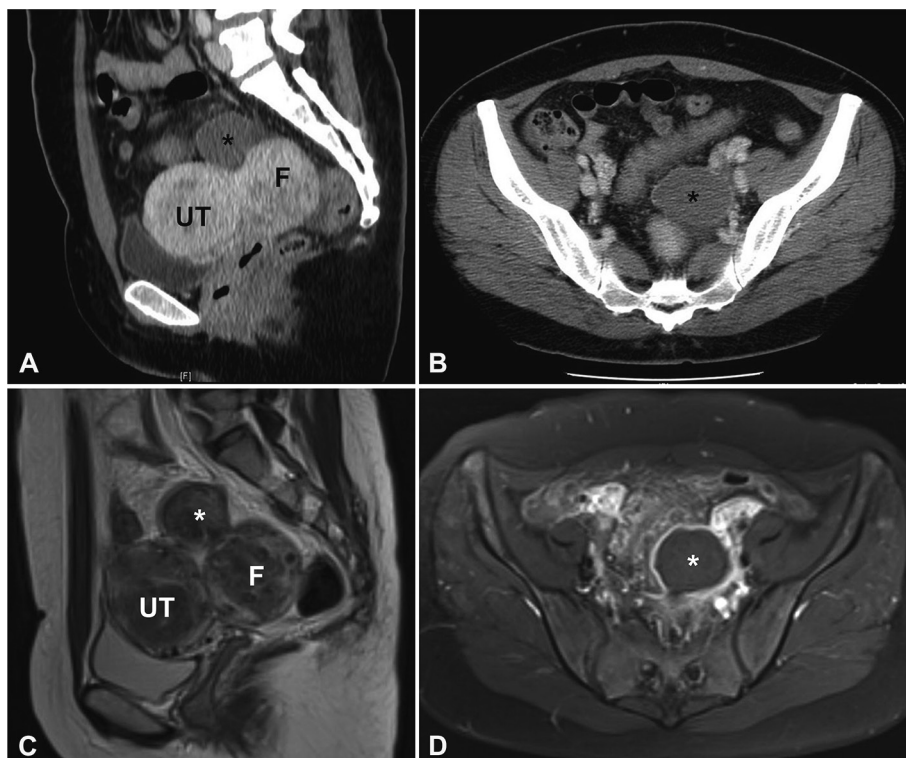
Computed tomography (CT) and magnetic resonance imaging (MRI) of the torsional subserosal uterine fibroid
